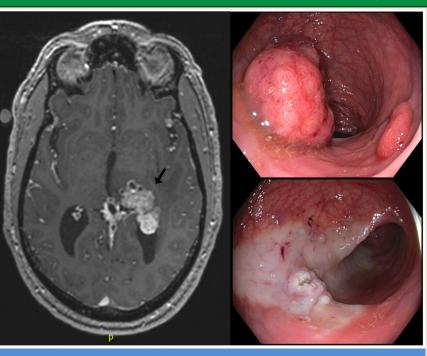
Brain MRI demonstrating metastasis to the left thalamus (black arrow). On right Colonoscopy images showing a fungating mass in the rectum and post hot-snare polypectomy.
